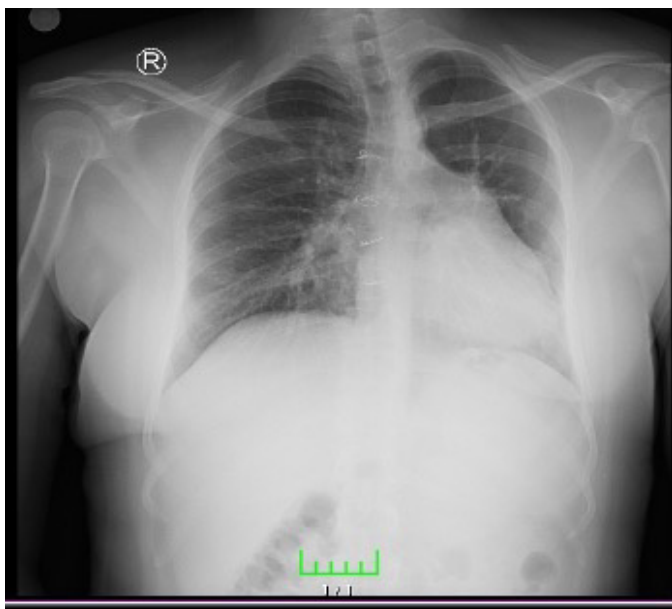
On chest X-ray, the vascularity of the right lung was increased, and the heart and mediastinal structures were observed to be deviated to the left
